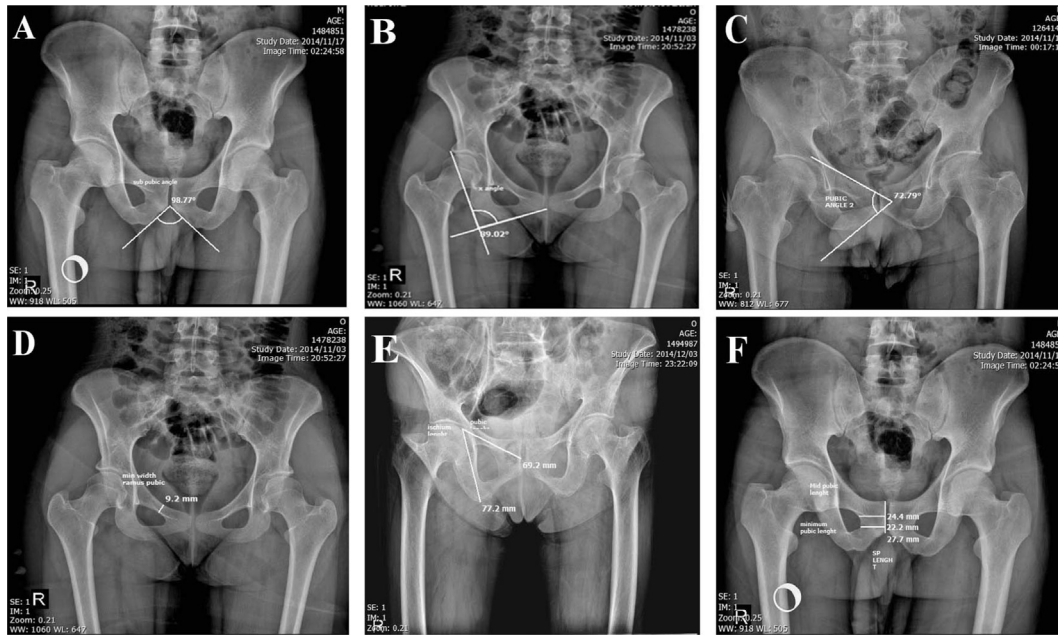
Ways of measurement of various parameters using anteroposterior pelvic radiographs. (A) Subpubic angle. (B) X angle. (C) Pubic Angle 2. (D) Minimum width of pubic superior ramus. (E) Length of the ischium and pubis. (F) Symphysis pubis length and the mid and minimum width of the pubis body.
